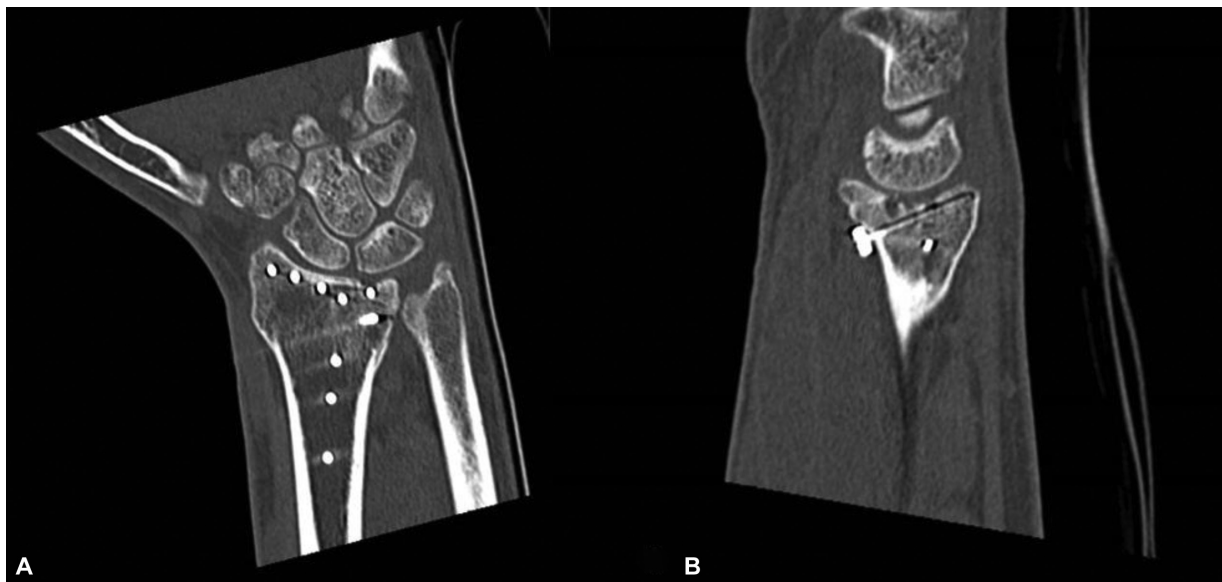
(A) Preoperative computed tomography (CT) scan of an osteochondral defect of the lunate facet in case 1. (B) Lateral CT scan of an osteochondral defect of the lunate facet in case 1.
